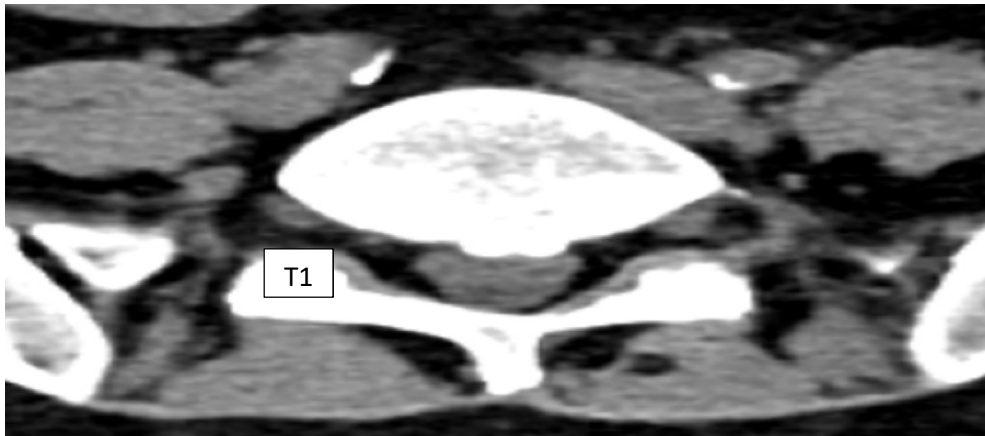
upper zone axial CT. Shows IAP, lamina some lateral ligamentum flavum, open bilateral foramina.
